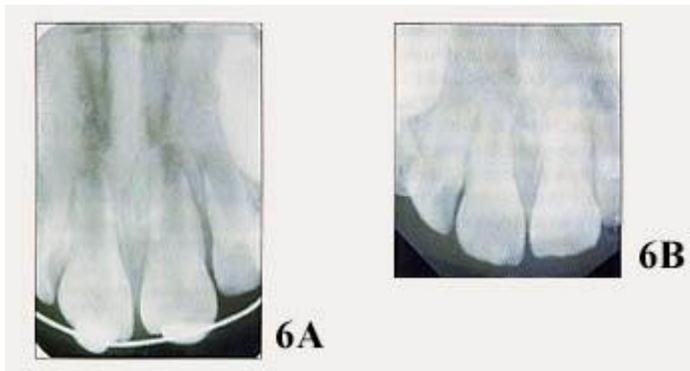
Immature maxillary central incisors that have revascularized after replantation. A radiograph made at the time of replantation and splinting (courtesy Dr. Joe Camp).
